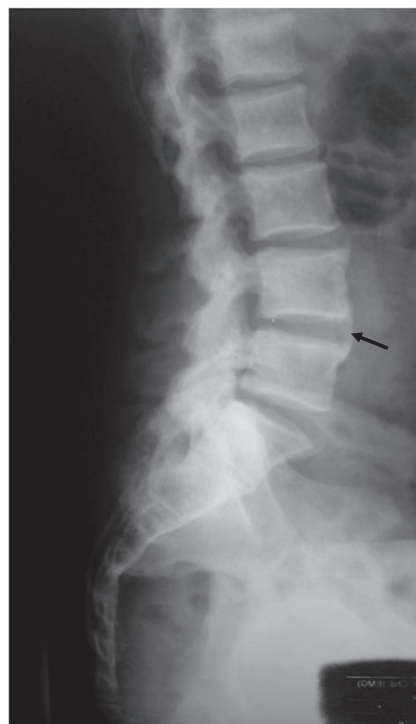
X-ray lumbosacral spine showing increased sclerosis with calcified interspinous ligaments.
